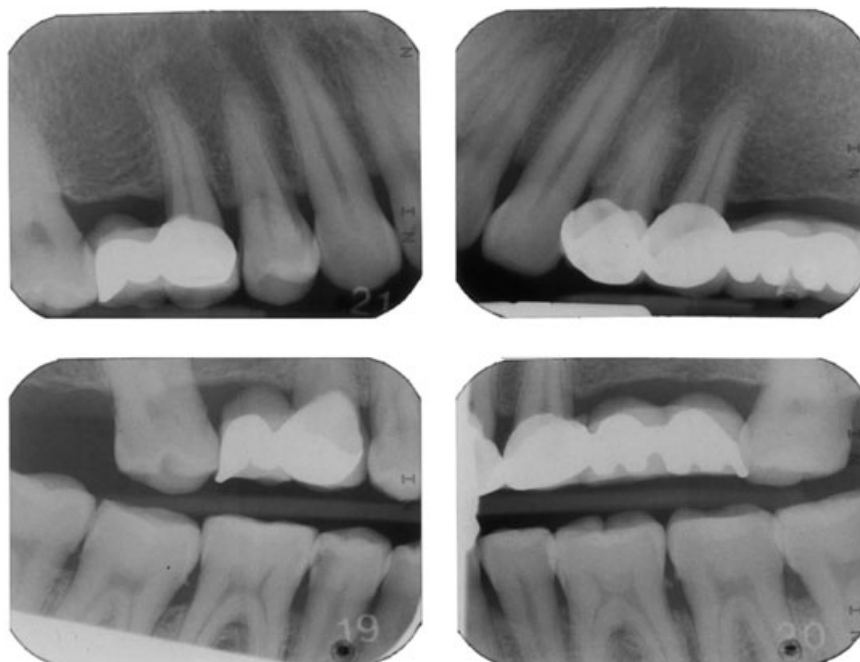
Peri-apical & bitewing radiographs show poor contacts, marginal deficiency (15) and caries distally in 45 (FDI notation).
